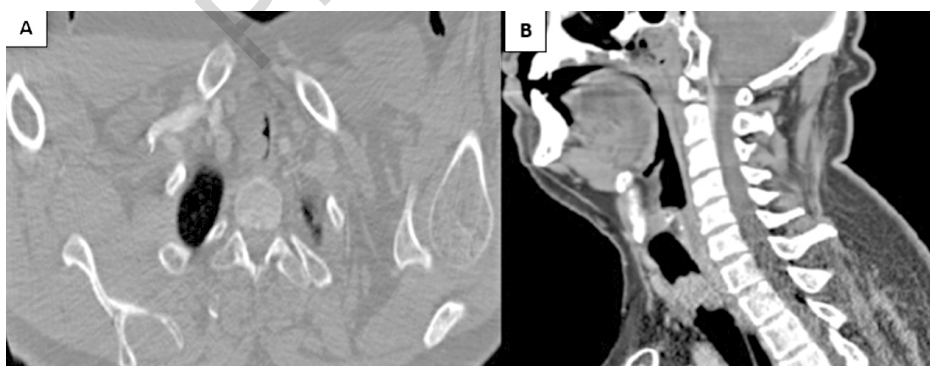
A-B) Computed tomography image of the mass narrowing the lumen of the trachea.
